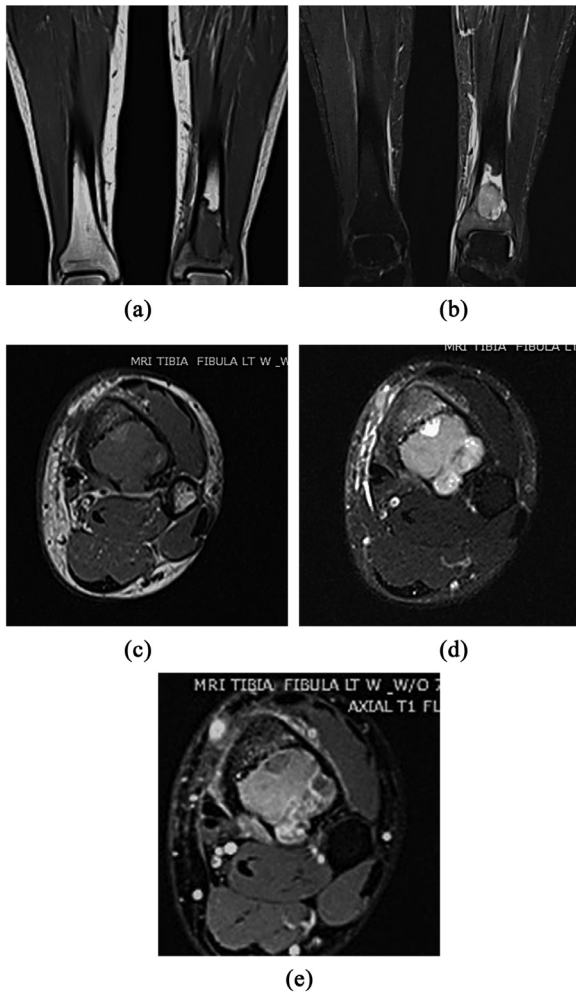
Contrast enhanced MRI of the left tibia fibula. Coronal T1 weighted, large field of view of both lower extremities (a) demonstrates a cellular, intermediate signal lesion in the medullary cavity of the distal left tibia; corresponding T2 weighted, large field of view (b) image demonstrates surrounding marrow edema, suggestive of an infiltrative, aggressive lesion. Dedicated, small field of view, pre-contrast, axial T1 (c) and T2 weighted, fat saturated (d) images of the left lower extremity reveal pronounced endosteal scalloping/erosion and frank cortical breakthrough posteriorly, indicative of an aggressive neoplasm. A post-contrast, axial, T1 weighted, fat saturated image demonstrates non-specific, heterogeneous enhancement, consistent with neoplasm.
